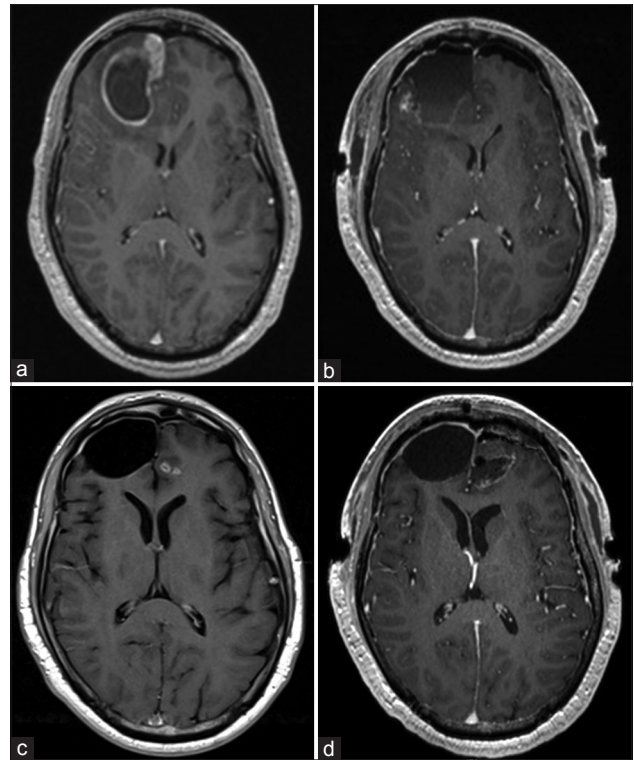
(a) MRI brain with contrast demonstrated 4.7 cm multiloculated rim enhancing cystic lesion with additional smaller projections invading the right frontal lobe with associated vasogenic edema and midline shift. (b) MRI brain with contrast demonstrating resection of right frontal mass with expected postoperative changes. (c) MRI brain with contrast demonstrating enhancing foci within left frontal lobe adjacent to prior surgical cavity. (d) MRI brain with contrast demonstrating resection of left frontal foci with expected postoperative changes
